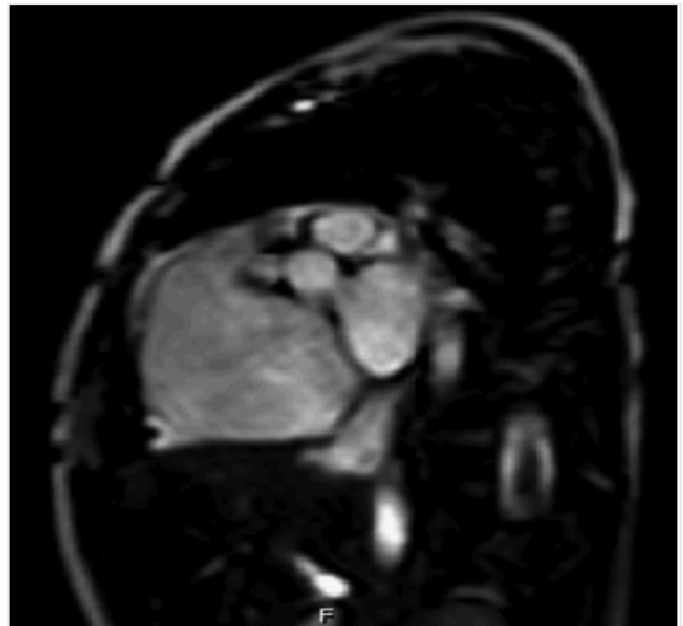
Magnetic resonance imaging of a 3-year-old patient with suspected ARVD shows enlargement of right ventricular outflow tract
